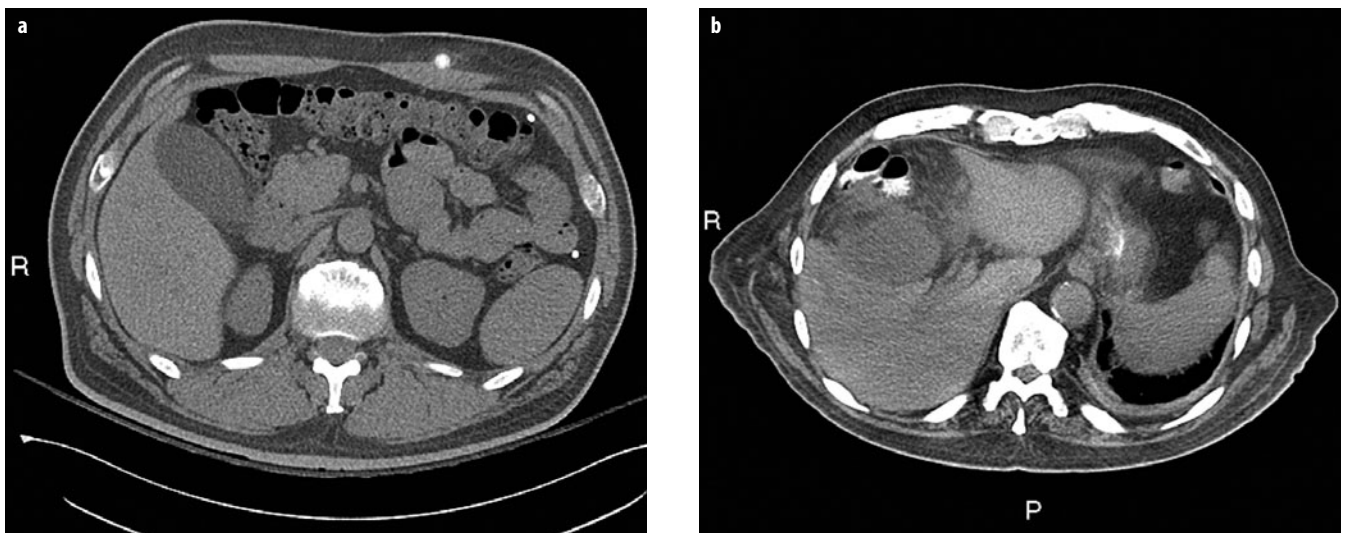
a, b. a A 46-year-old man with acute right flank and right mid-abdominal pain, with suspected urolithiasis and previous gastric banding. Noncontrast computed tomography (CT) image shows a mildly distended gallbladder, with subtle wall thickening and inflammation adjacent to the gallbladder neck. CT correctly demonstrated acute cholecystitis, although subsequent ultrasound (US) findings (not shown) were more obvious and confirmatory. b A 76-year-old man with renal dysfunction, diabetes, and *Escherichia coli* bacteremia. Axial computed tomographic (CT) image, performed with orally administered contrast only, shows prominent focal inflammatory changes associated with a distended gallbladder, which proved to be due to gangrenous cholecystitis. There is also interposition of the hepatic flexure of the colon anterior to the liver, with associated liver remodeling. Inflammatory changes spread to the adjacent colon
